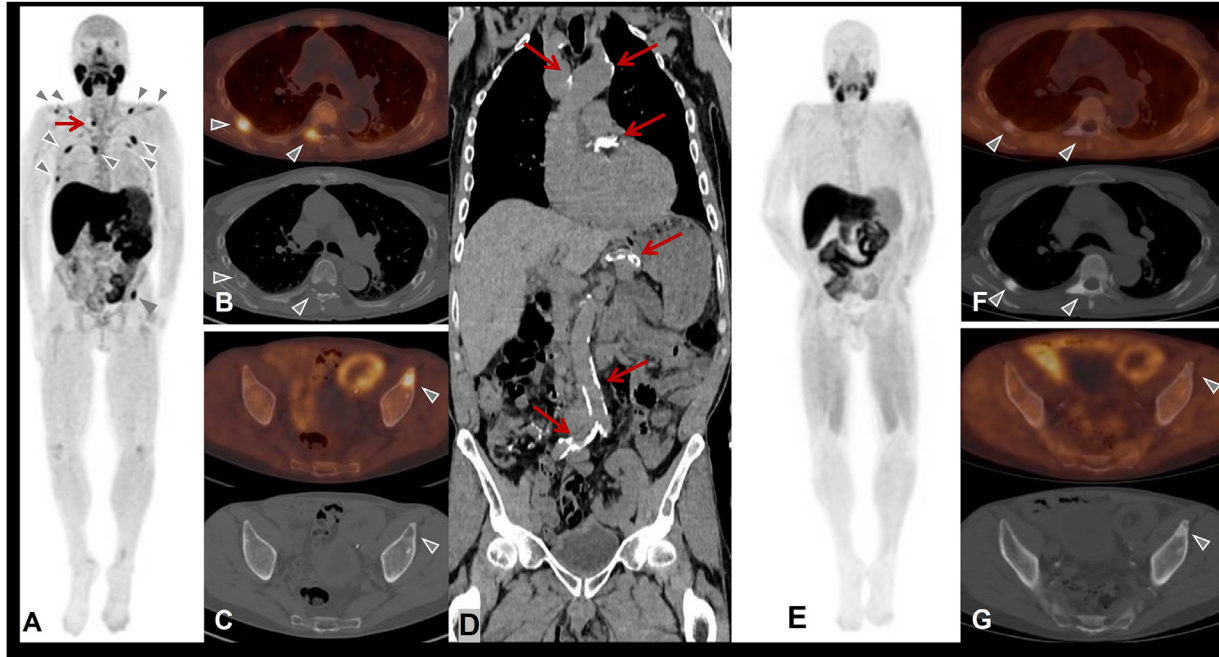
Patient on haemodialysis for 8 years with rejection of 2 kidney grafts. Parathyroidectomy of both superior and the left inferior hyperplastic parathyroid glands (RP4, LP4, LP3) has been performed, but 2 months later, serum parathyroid hormone level increased to 1300 ng/L. Hence FCH PET/CT was performed and showed a right inferior hyperfunctioning parathyroid gland (RP3) SUVmax 14.71 (A, arrow) but also numerous skeletal foci (A, B, C, arrow heads), osteolytic on low dose CT image (B, C) and generalized atherosclerosis (D, arrows). (A, E) MIP, (B, C, F, G) PET/CT and CT, axial slice, (D) CT, coronal slice, Following right inferior parathyroidectomy (more than 7/8 of PTs resected) the serum parathyroid hormone level dropped to 185 ng/L. On FCH PET/CT performed 5 months after this parathyroidectomy, the bone foci disappeared on PET and the corresponding osteopenic lesions on CT showed remineralization (arrow heads), permitting to conclude that they corresponded to brown bone tumors.
